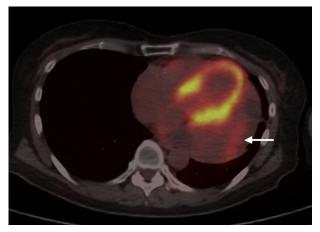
FDG PET/CT demonstrating radiotracer uptake in the solid part of the pericardial mass (white arrow). Maximum standardized uptake value is 3.48.
